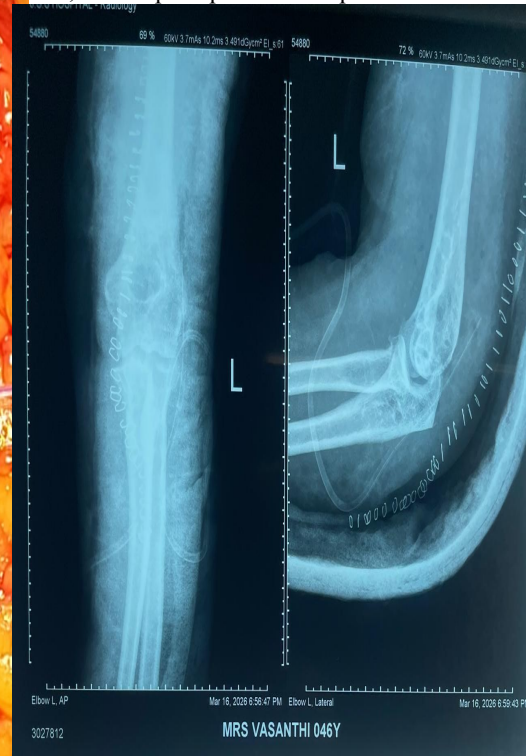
Postoperative plain radiographs (AP and lateral views, left elbow, demonstrating satisfactory restoration of the radiocapitellar relationship and anatomical alignment of the elbow joint following collateral ligament reconstruction.
